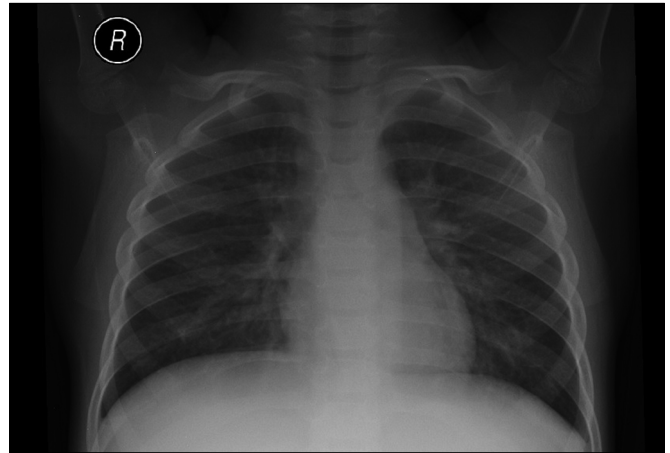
Normal thoracic X-ray.
